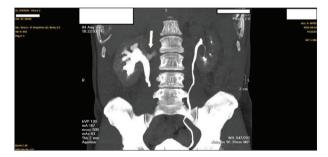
Preoperative CT scan: spontaneous rupture of the fornix of the upper calyx of the right kidney and a small leakage of contrast (arrow)
